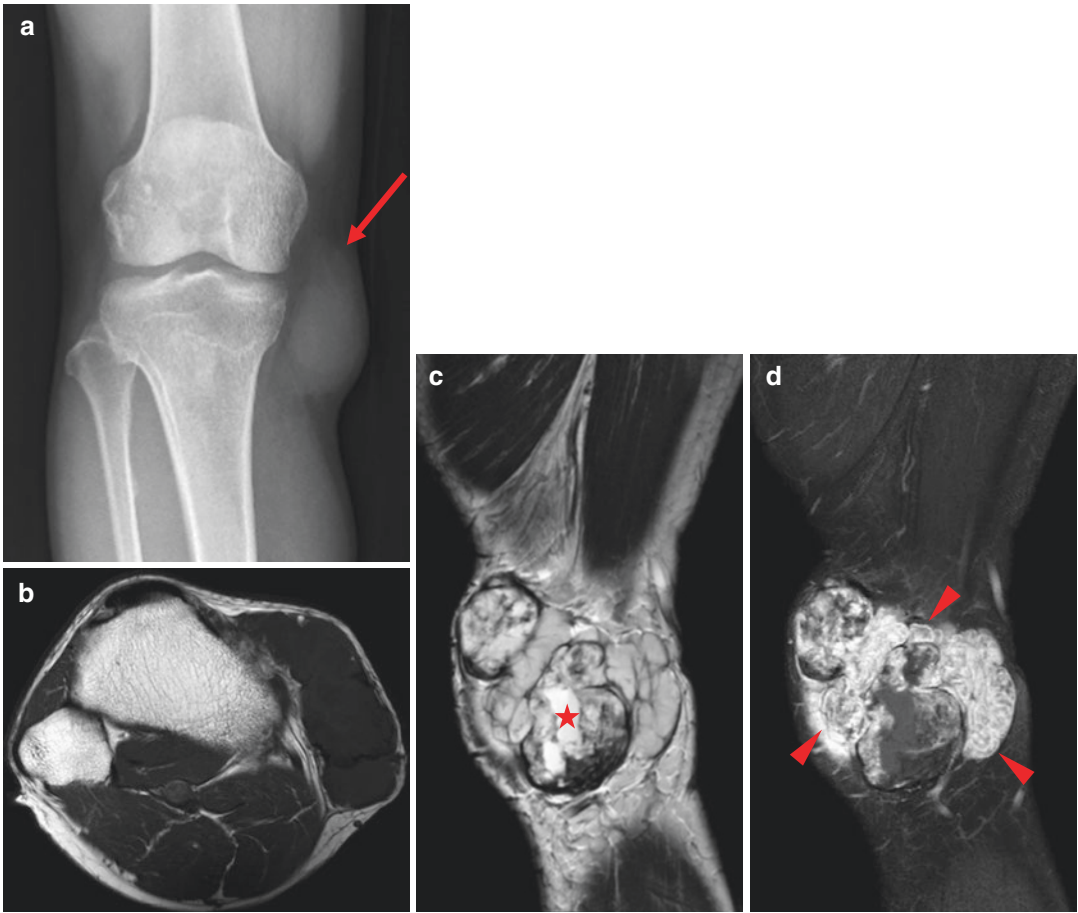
Extraskelatal myxoid chondrosarcoma. AP radiograph of the knee (a) shows nonspecific soft tissue mass (*arrow*) in the medial knee that does not contain calcifications or exhibits bone formation. Axial T1WI (b) reveals a subcutaneous mass in the medial aspect of the proximal tibia. The tumor is isointense to the adjacent
